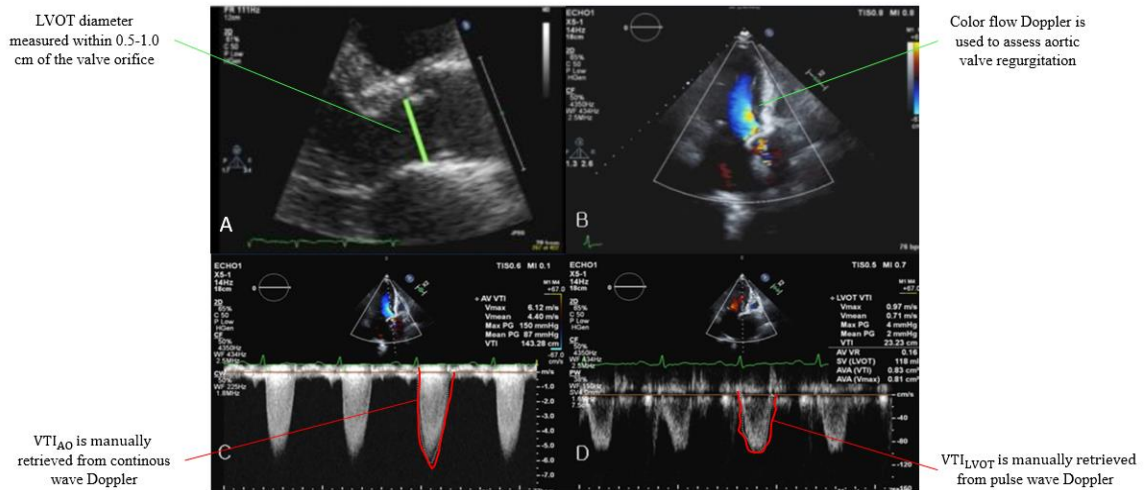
Transthoracic echocardiography: in order to compute the aortic valve cross-sectional area, the Left Ventricular Outflow Tract diameter (A), the Velocity Time Integral of the flow at the level of the aortic orifice (C) and of the LVOT (D) are manually extracted from TTE Doppler images. Moreover, Color flow Doppler can be useful for a visual assessment of the aortic regurgitation (B). Transthoracic echocardiogram reveals severe aortic valve stenosis (AS), with peak velocity through the aortic valve equal to 6.12 m/sec and a mean pressure gradient equal to 87.0 mmHg. The aortic valve area, calculated by continuity equation, is 0.81 cm²
